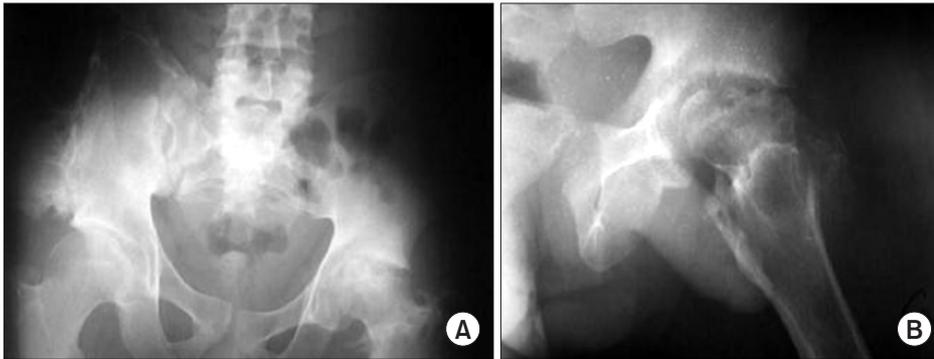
Pelvic plain radiography showed advanced osteonecrosis and osteoarthritis on the left hip at 12 months postoperatively. (A) Frontal plane. (B) Sagittal plane.
